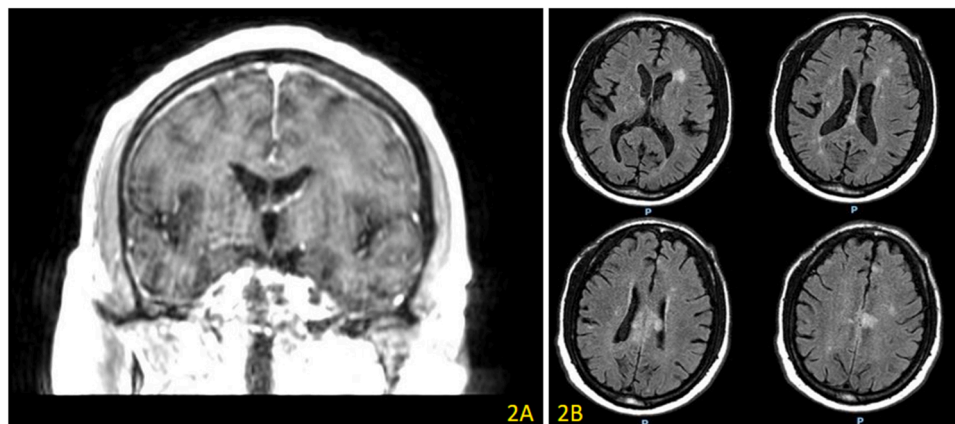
MRI brain with and without IV contrast shows leptomenigeal disease in the subfalicine and arachnoid spaces extending into the cingulate sulci and supracallosal arachnoid spaces (2A) and multiple lobulated foci within the arachnoid spaces and surrounding cortical tissues consistent with an arachnoid space empyema and multiple focal cortical gray matter abscesses (2B).
